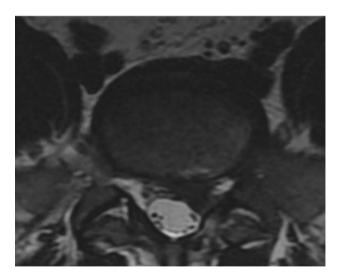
Preoperative axial T2 MRI of the L5-S1 segment showing massive left disc herniation determining left lateral recess obliteration and root compression
